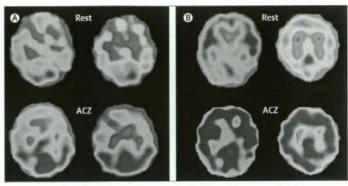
Preoperative and postoperative SPECT in paediatric patients with moyamoya disease
